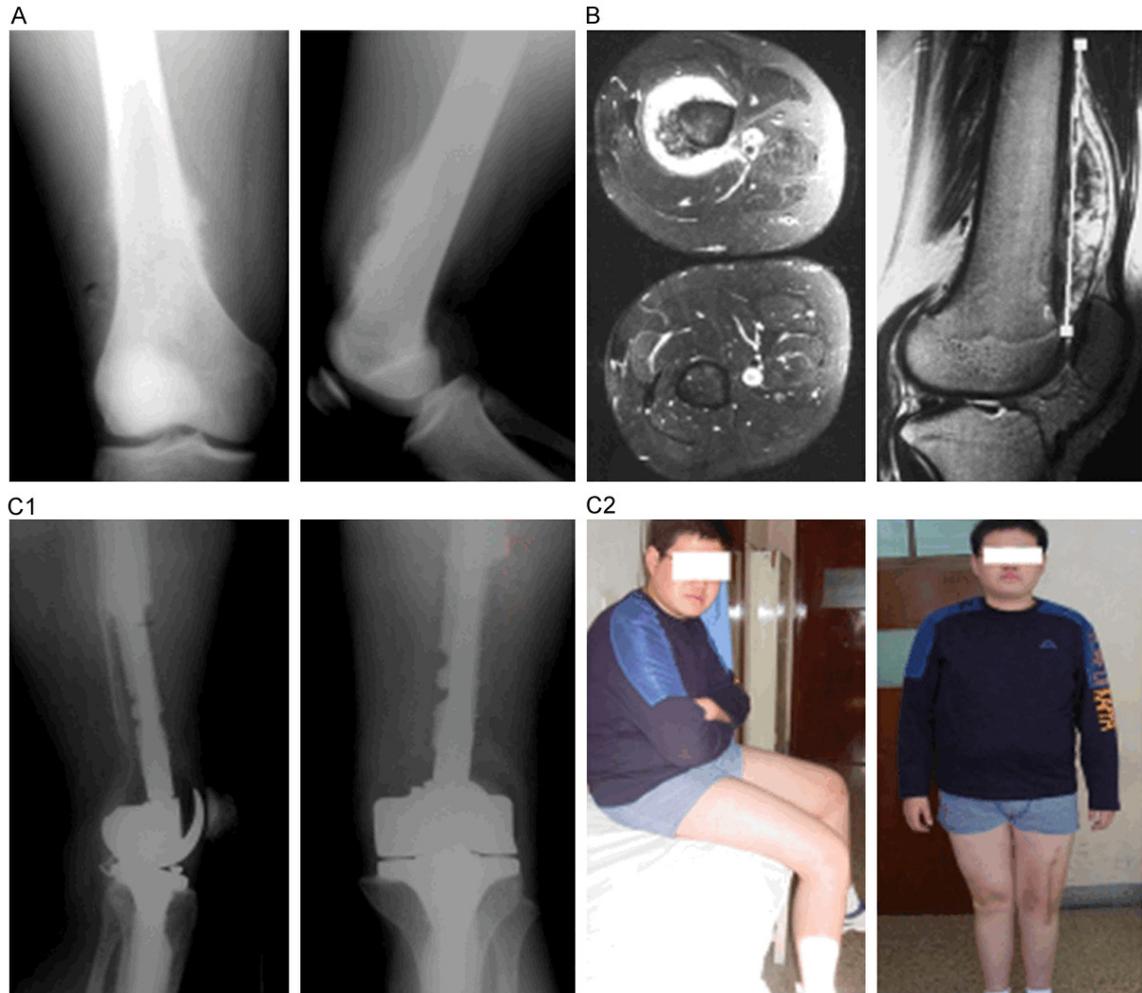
Preoperative imaging and functional outcomes in a 16-year-old male patient with sarcoma at the distal femur. Shown are (A) preoperative X-ray images, (B) preoperative MRI images, (C) X-ray (C1) and functional (C2) image at 9-years postoperative.
